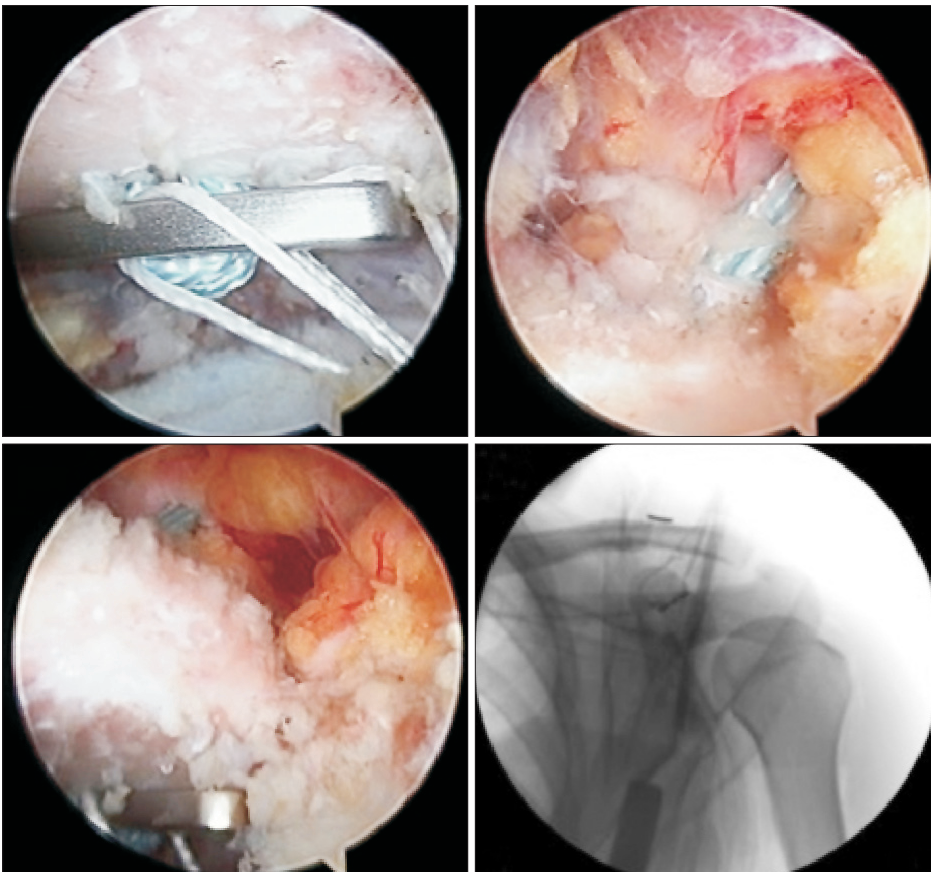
Anatomical reduction of the acromioclavicular joint under direct visualization and radiographic control.
